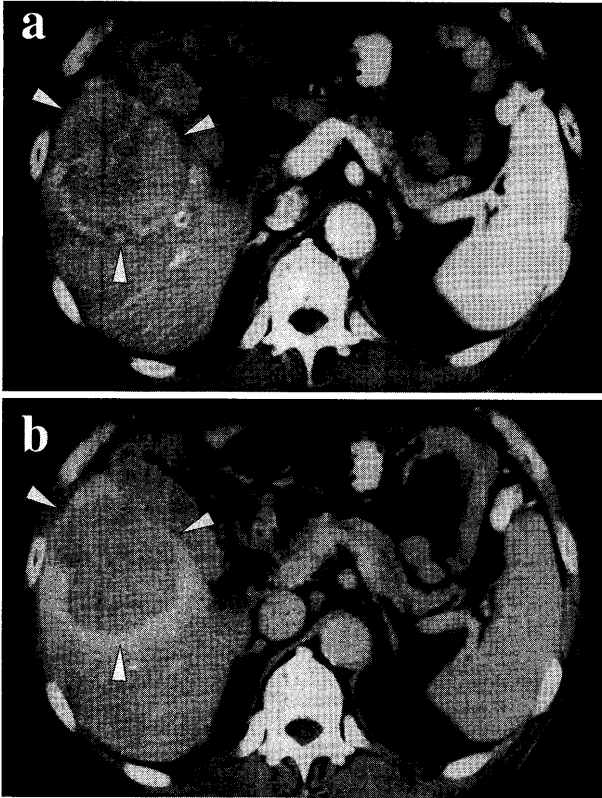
Dynamic CT performed on 7 days after admission showed the enhancement of central part of the lesion in the early phase (a), but only the margin was enhanced in the late phase (b).
